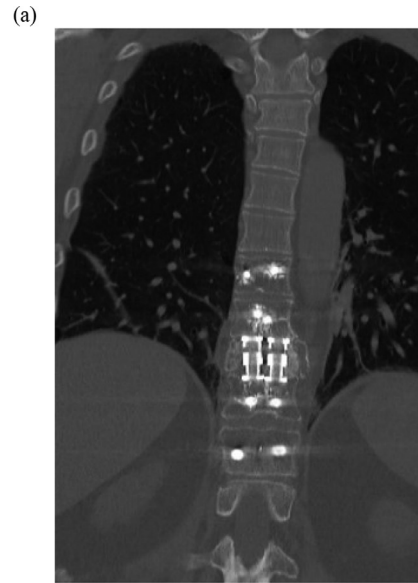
Coronal (a) and axial (b) CT Thoracic Spine Without IV Contrast at 6-month follow up showing arthrodesis across the corpectomy defect
